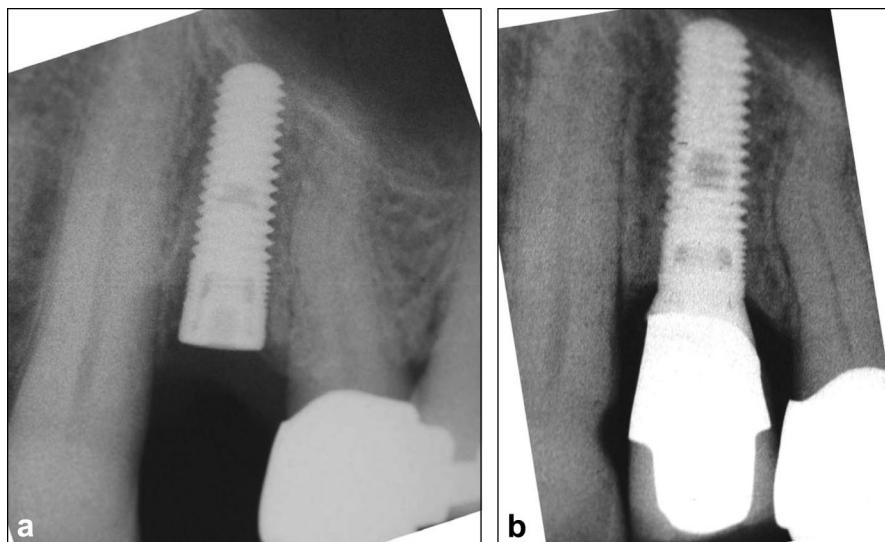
a, Radiograph of Screwplant placed into a fresh extraction socket. b, Radiograph of the same implant at 12 months of healing. Note that the first apparent BIC can be found at ~ 1 mm from the implant-abutment interface.
